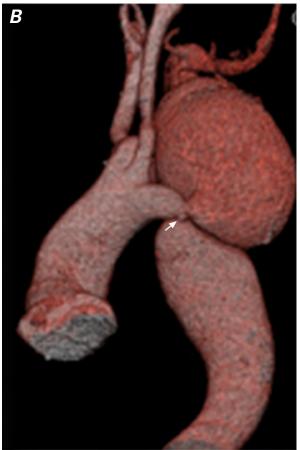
A) Magnetic resonance angiogram and B) postoperative volume-rendered computed tomogram show tight juxtaductal coarctation of the aorta (arrows).
